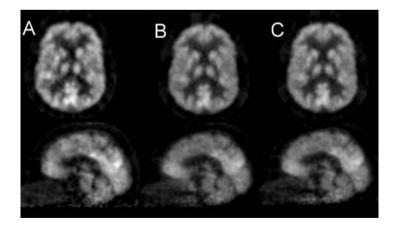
Reconstructed FDG images of the same patient and same cross-sections as in figure 1 after correction for attenuation with PBA (A) and MBA using M1 (B) and M4 (C)
